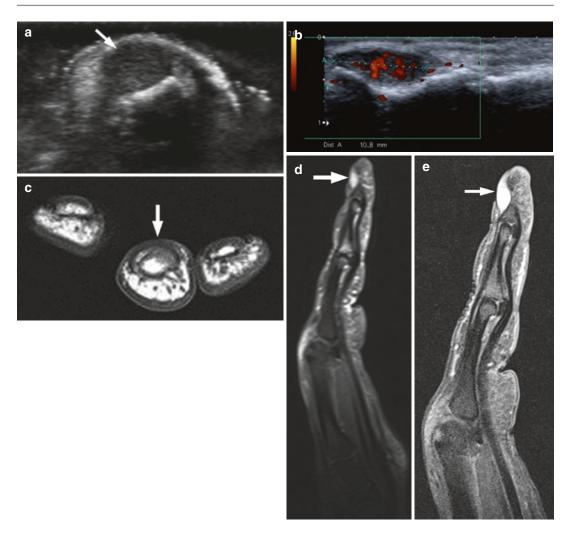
Glomus tumor of digitus 3 of the upper extremity in a 48-year-old woman. (a) Transverse ultrasound image. (b) Longitudinal ultrasound image with Doppler. Subungually located, hypoechoic mass with Doppler vascular signal and pressure erosion of the dorsal cortex of the distal phalanx. (c) Axial T1-WI. (d) Sagittal
